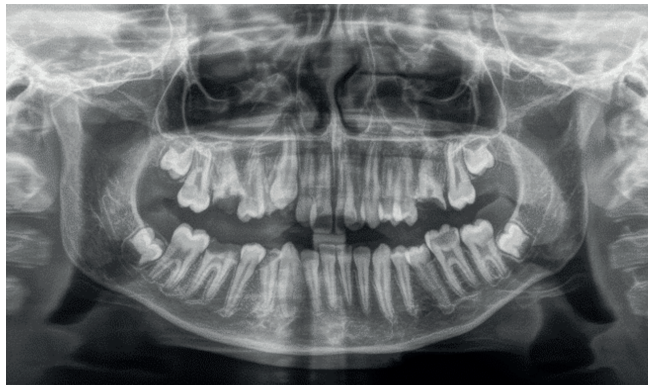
Pre-operative panoramic radiographic image (above).
